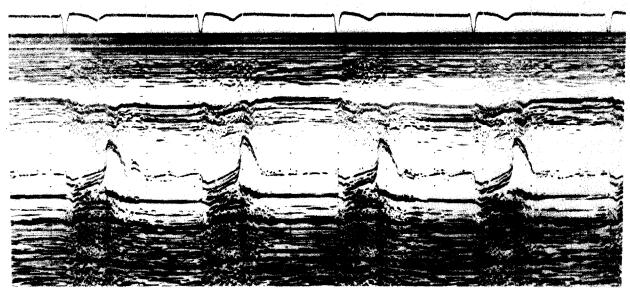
Echocardiogram of mitral valve. End-diastolic "atrial kick" or A wave of anterior mitral leaflet is absent.
